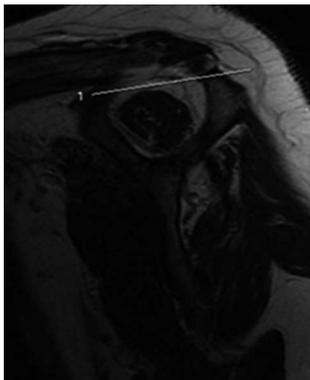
Supraspinatus muscle atrophy, tangent sign. Sagittal oblique T1-weighted image showing the upper border of supraspinatus muscle below the line extending between the scapular plate and spine.
